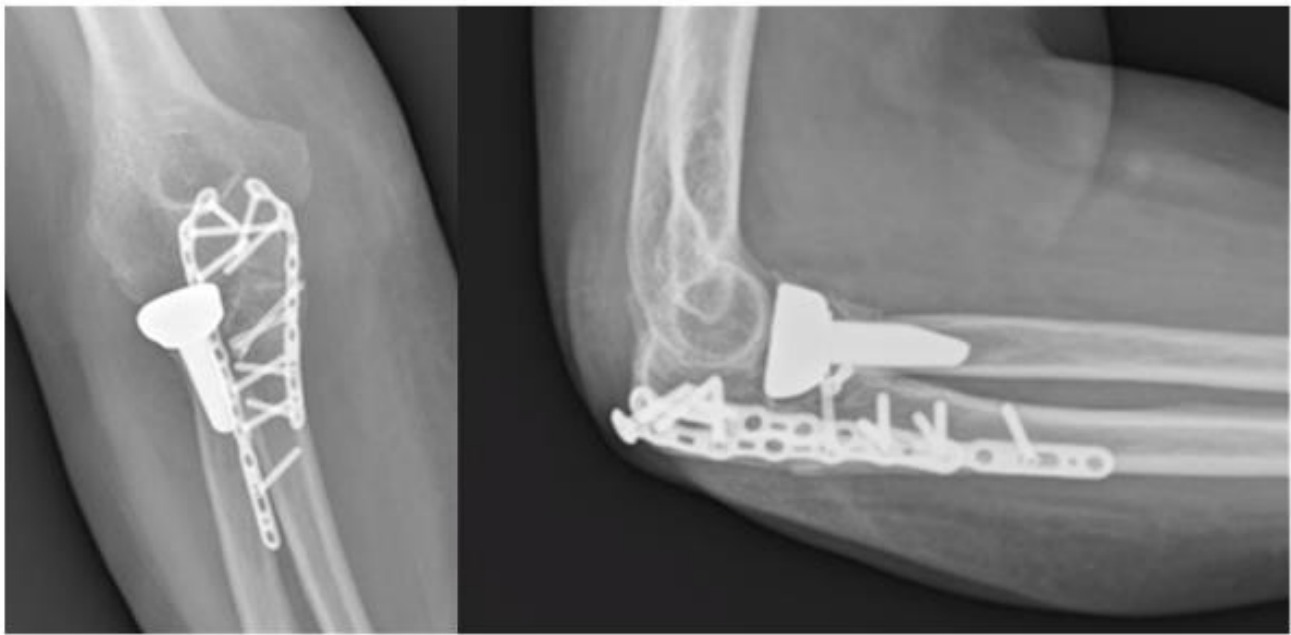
Case 3 – Anteroposterior and lateral radiographic check-up at 6 months
